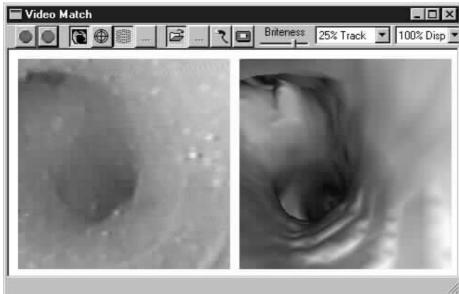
Examples of the *Video Match* tool. Top part is near the carina of the bronchoscopy training device. A surface-rendered endoluminal view is calculated and displayed that matches the live bronchoscopic video. A mutual-information optimization algorithm is run that adjusts the virtual system's viewpoint in the rendered CT to match the video viewpoint. The global position of this viewing site is indicated by the "+" in the *Coronal Slicer* view (a cross-section through the original 3D CT scan of the model). Bottom part of figure is at the second bifurcation point of the model. This image shows how a best match of the rendered CT to the video frame is done by weighting the dark values more than the light values. In both images the lighter areas contain inconsistent textures.
